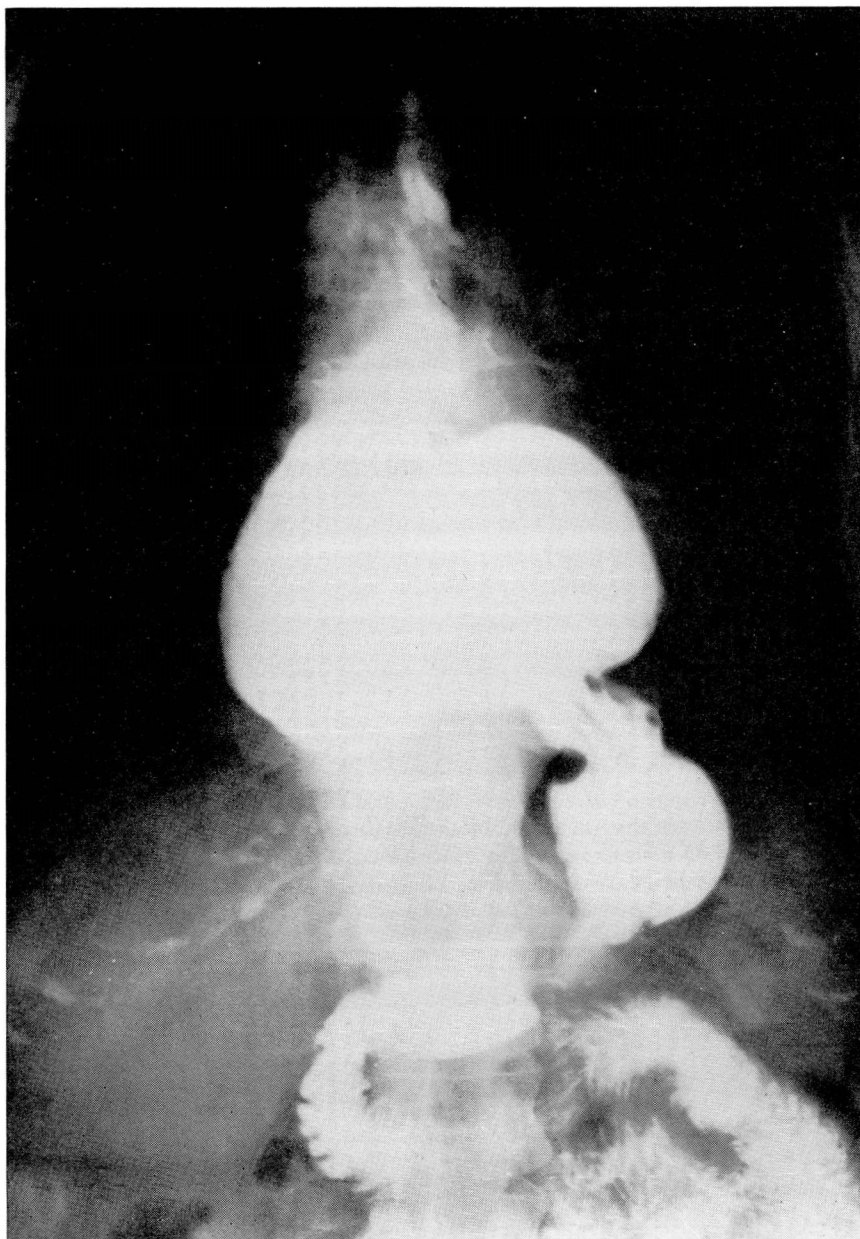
Roentgenogram showing a large esophageal hiatus hernia.
